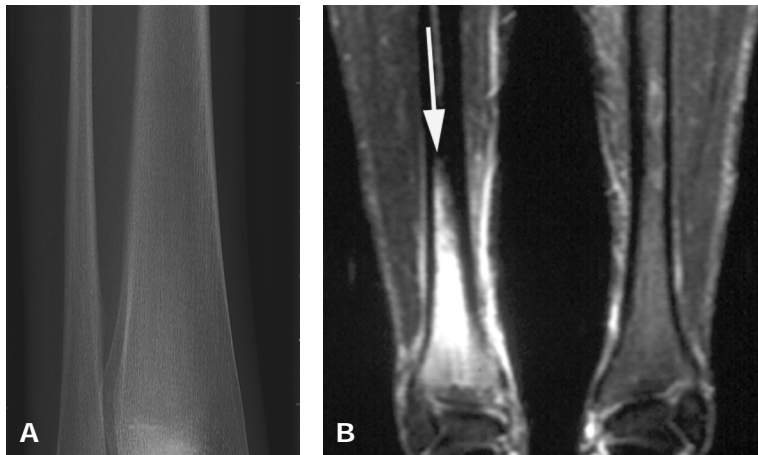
Stress response in the distal tibia in a 42-year-old male runner. A, Anteroposterior radiograph demonstrates no abnormalities. B, Coronal STIR T2-weighted MR image demonstrates diffuse high signal intensity (arrow) in the intramedullary space of the right tibia, representing bone marrow edema. The cortex shows no abnormalities.
